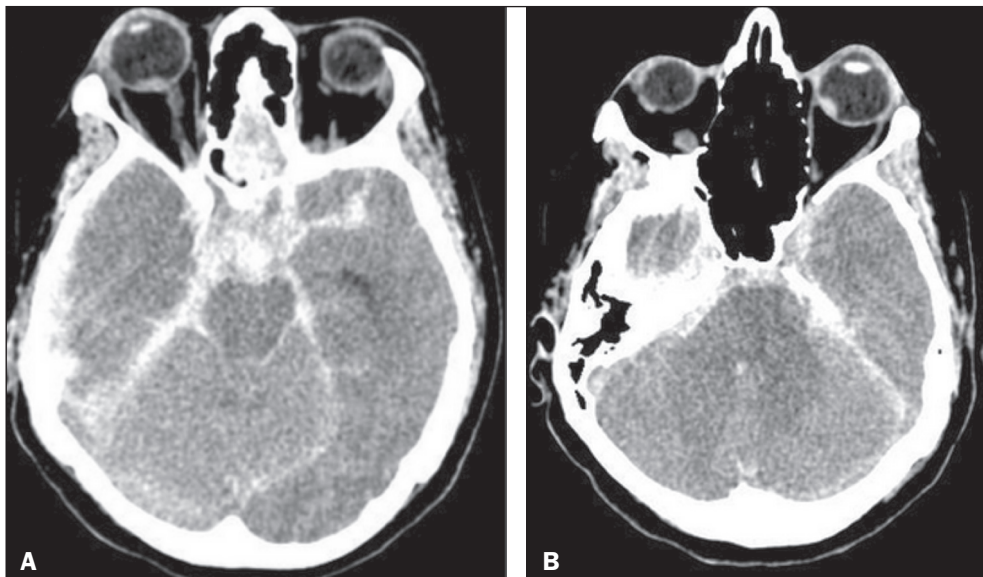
A: CT scan showing signs of subarachnoid hemorrhage and right intraocular hemorrhage, as a spontaneously hyperattenuating focus in the posterior portion of the right globe. B: CT scan showing left intraocular hemorrhage.
